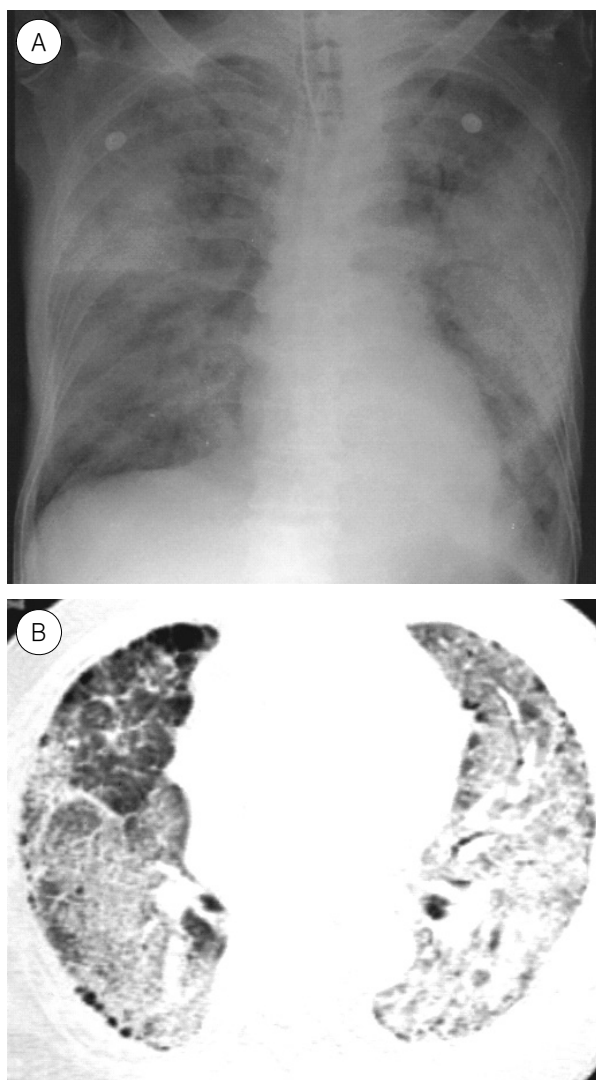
Acute interstitial pneumonia in a 57-year-old woman. (A) Chest radiograph shows extensive and patchy areas of consolidation in both lungs. (B) HRCT scan obtained at level of right inferior pulmonary vein shows mixed consolidation and ground glass opacity with minute reticular opacities in both lungs. Also note subpleural distribution of paraseptal emphysema.
